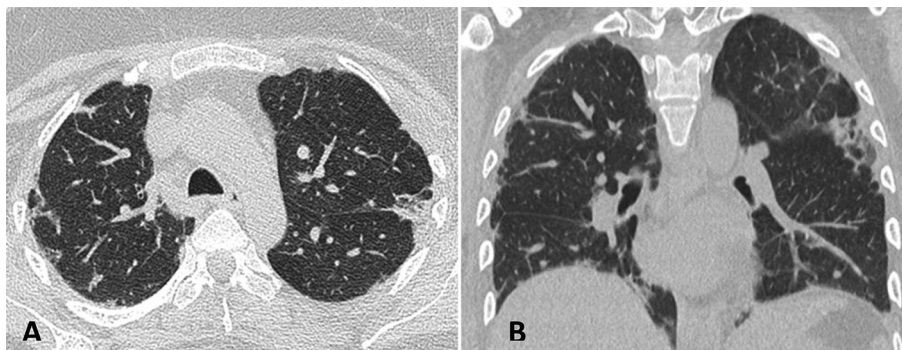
High resolution computerized tomography (HRCT) chest axial view (A) coronal anterior view (B) showed patchy ground-glass appearance in both lung fields, more extensive in the periphery of the left lung and characteristic predominance of abnormalities in subpleural and basal regions.
